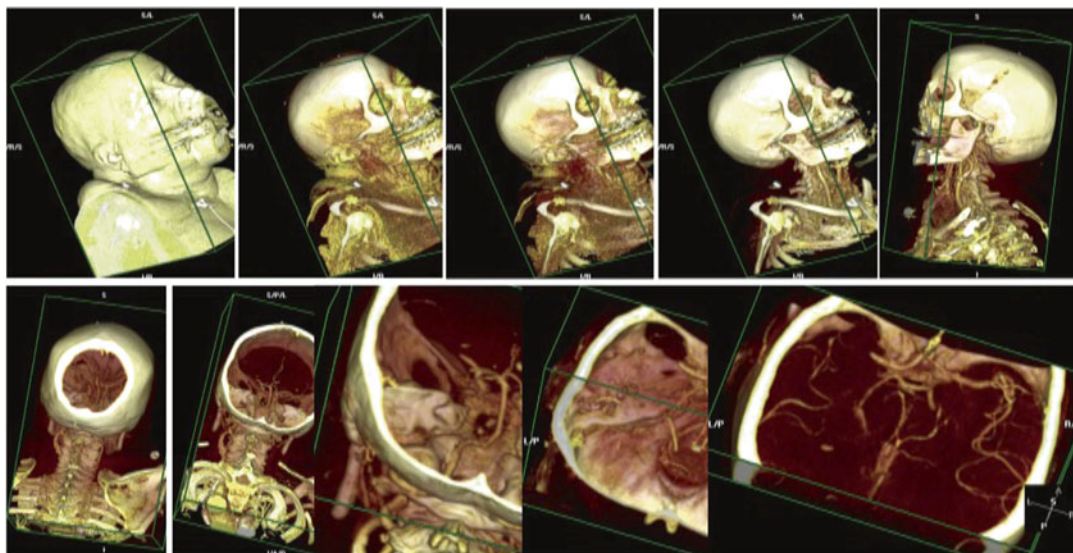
Rapid determination of the site and severity of obstruction using CT angiography
